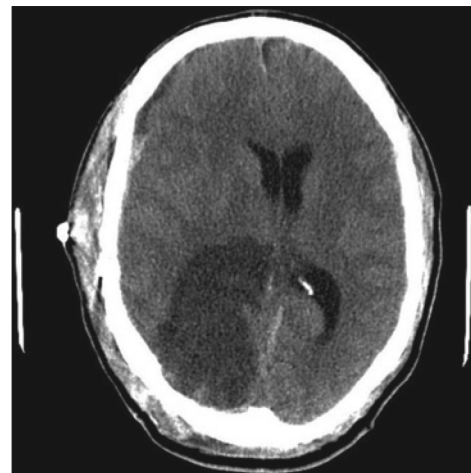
Non-contrast head CT showing large right occipital hypodensity consistent with PCA territory stroke
